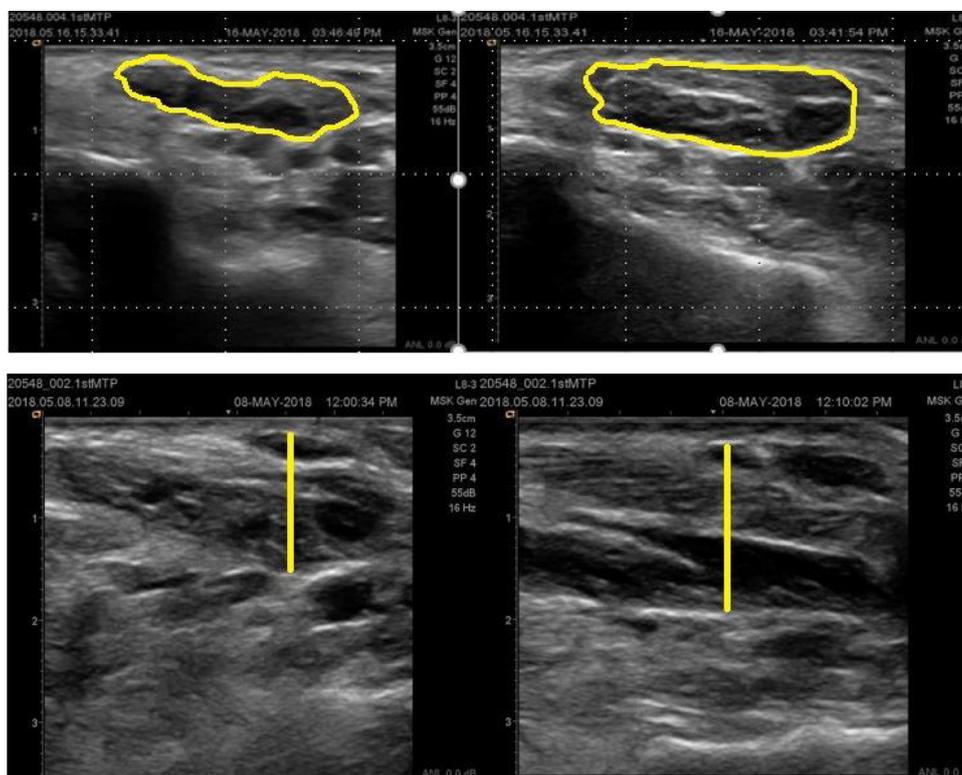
Measured Ultrasound Images of Abductor Hallucis CSA and MT in sitting position. The top images are measured CSA and the bottom are measured MT. Left side images are for the surgical toe and the right sided images are for the non-surgical toe.
